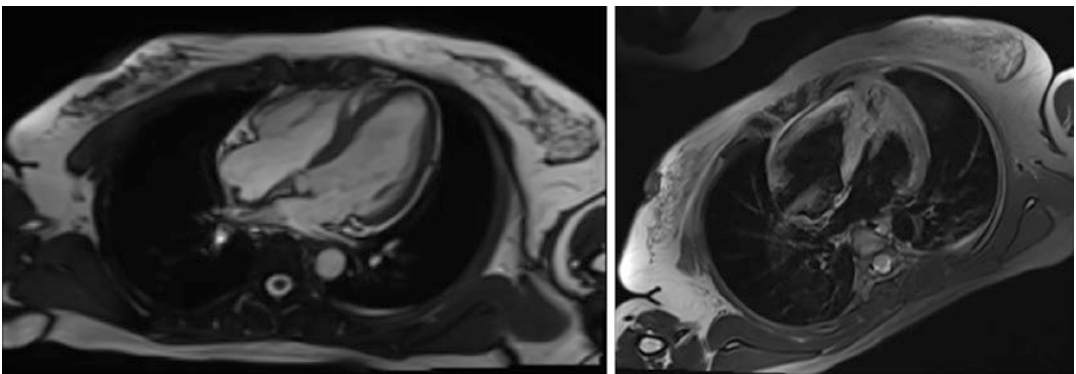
One week after admission, cardiac magnetic resonance image showing myocardial edema and necrosis in the ventricular septum, and anterior and inferior wall of left ventricle
